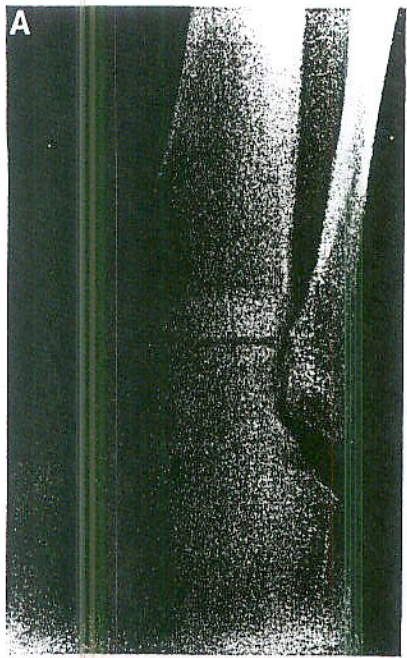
A, Mortise view of the left ankle; avulsion fracture of the calcaneus at the insertion of the calcaneal-fibular ligament. B, Lateral left ankle view: normal radiograph.
